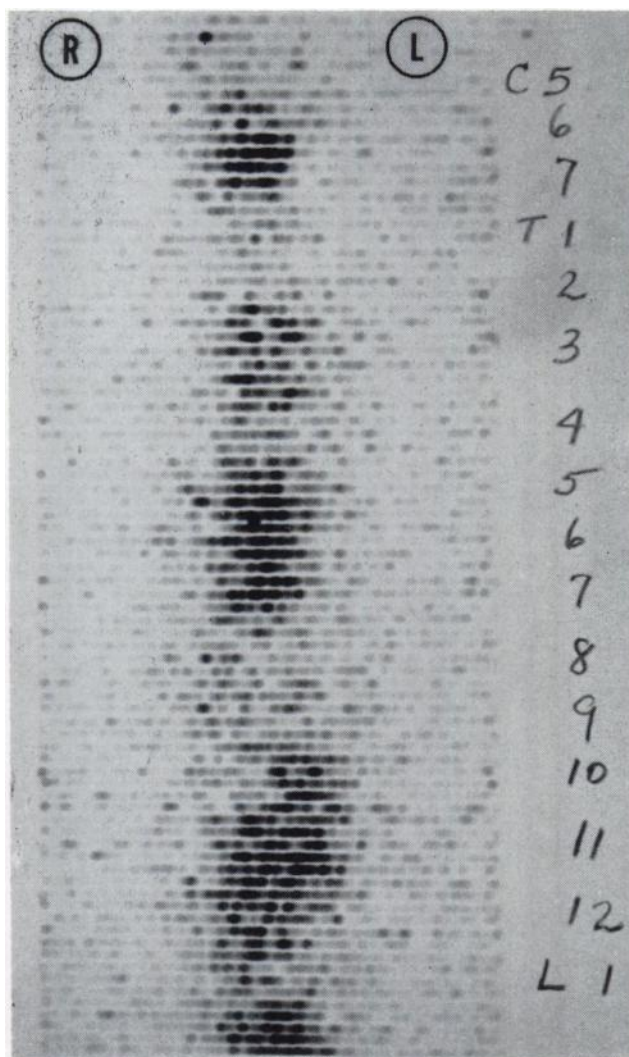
Scan of dorsal spine of 42 year old female with history of radical mastectomy for carcinoma and pathologic fracture of left ischium. Note markedly increased Sr^{85} deposition in C-6, 7; T-3,5,6,7,10 through L-2. Patient had no pain and roentgenograms were negative at time of scan. Back pain later developed and responded to x-ray therapy.
